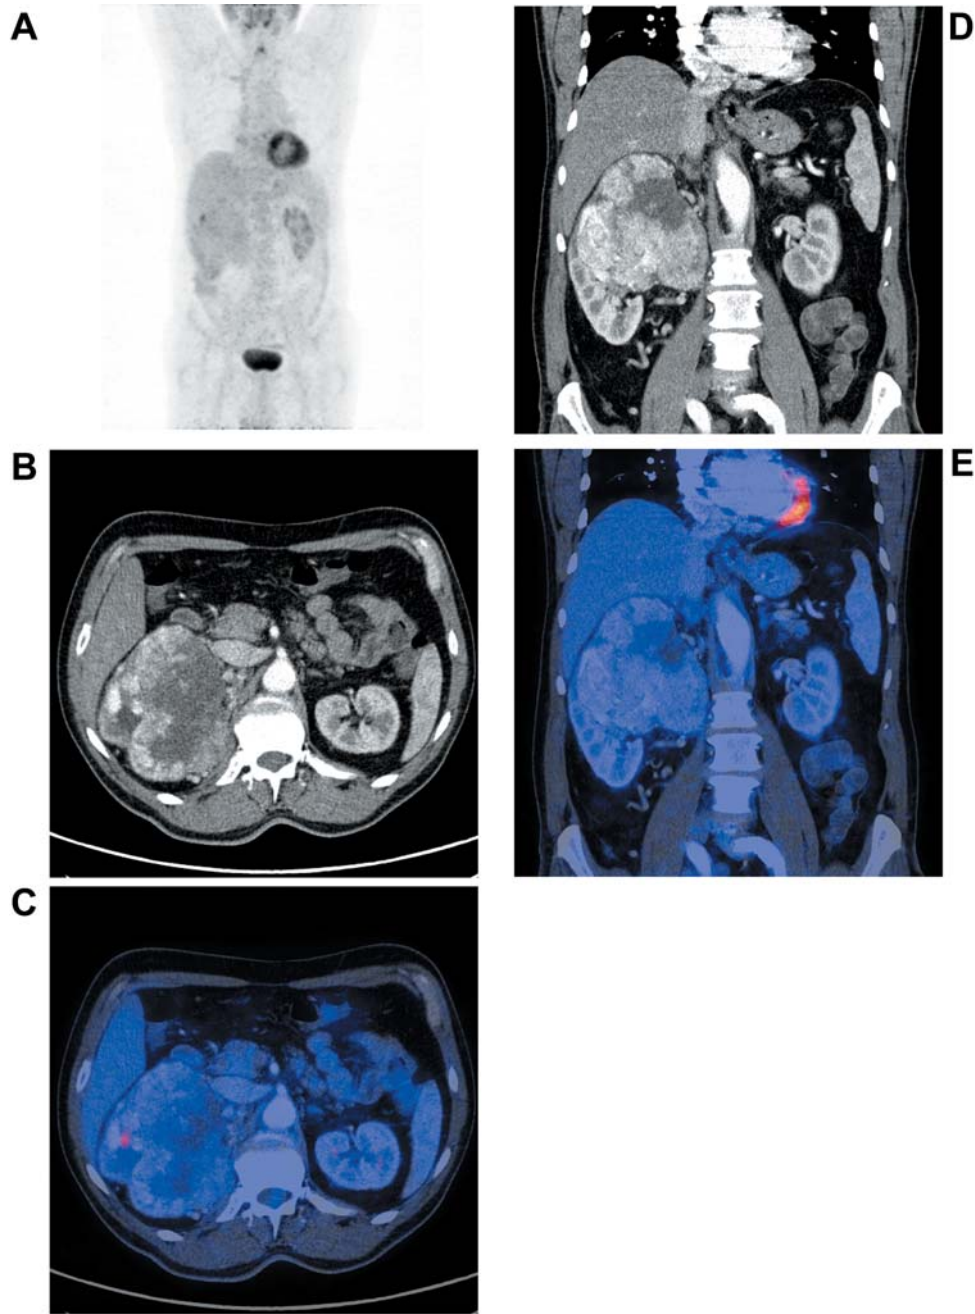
patient surviving more than 24 months after nephrectomy, conventional renal cell carcinoma well differentiated with low level accumulation of FDG. A – whole body MIP PET; B, D – CT images, C, E – PET/CT fusions – levels of displayed  $SUV_{max}$  0-10.
